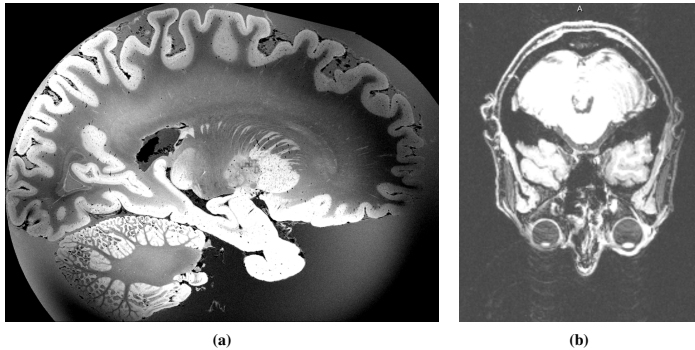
Examples of artifacts in MRI data: (a) strong intensity inhomogeneities and (b) ghosting artifact (bottom part, below the eyes).
